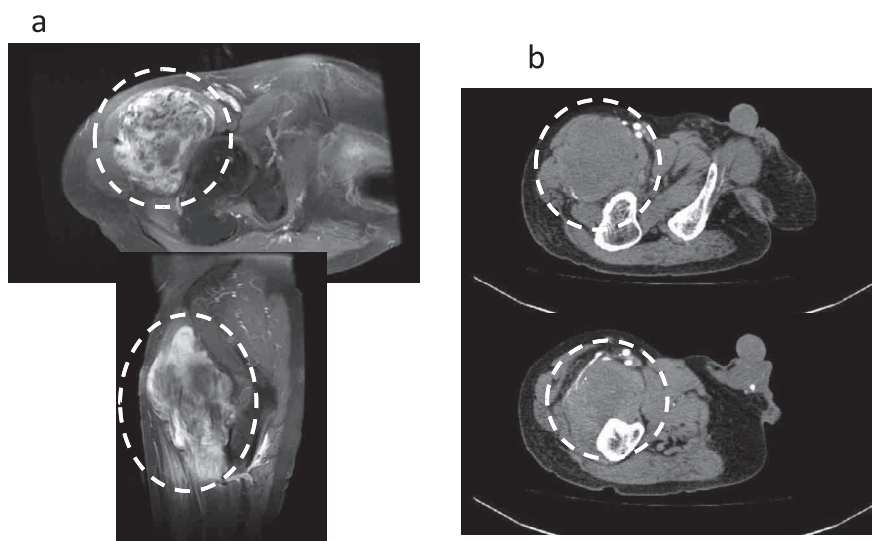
Case 9. A 78-year-old man with a liposarcoma of the right femoral region. Tumor size was $8 \times 6 \times 15$ cm ; a : MRI CE Fat Sat T1WI axial & sagittal view, b : enhanced CT.
